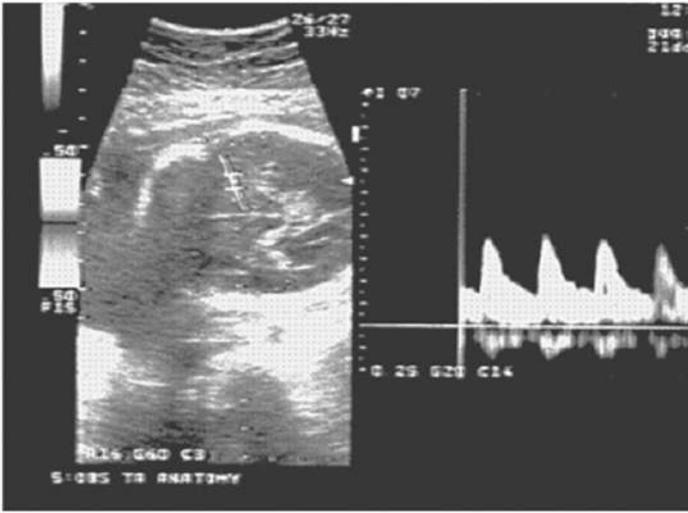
Middle cerebral artery Doppler showing increased diastolic flow with possible redistribution to brain in hypoxia.
